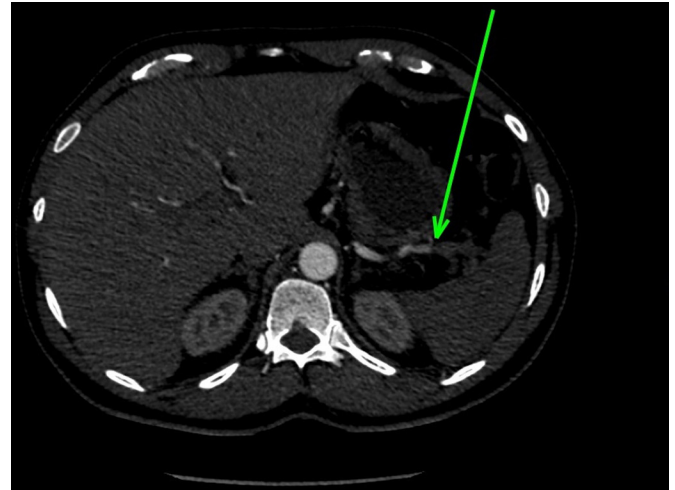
CT abdomen arterial phase imaging demonstrates thromboembolic material within the splenic artery (indicated by arrow) causing near complete splenic infarction.
